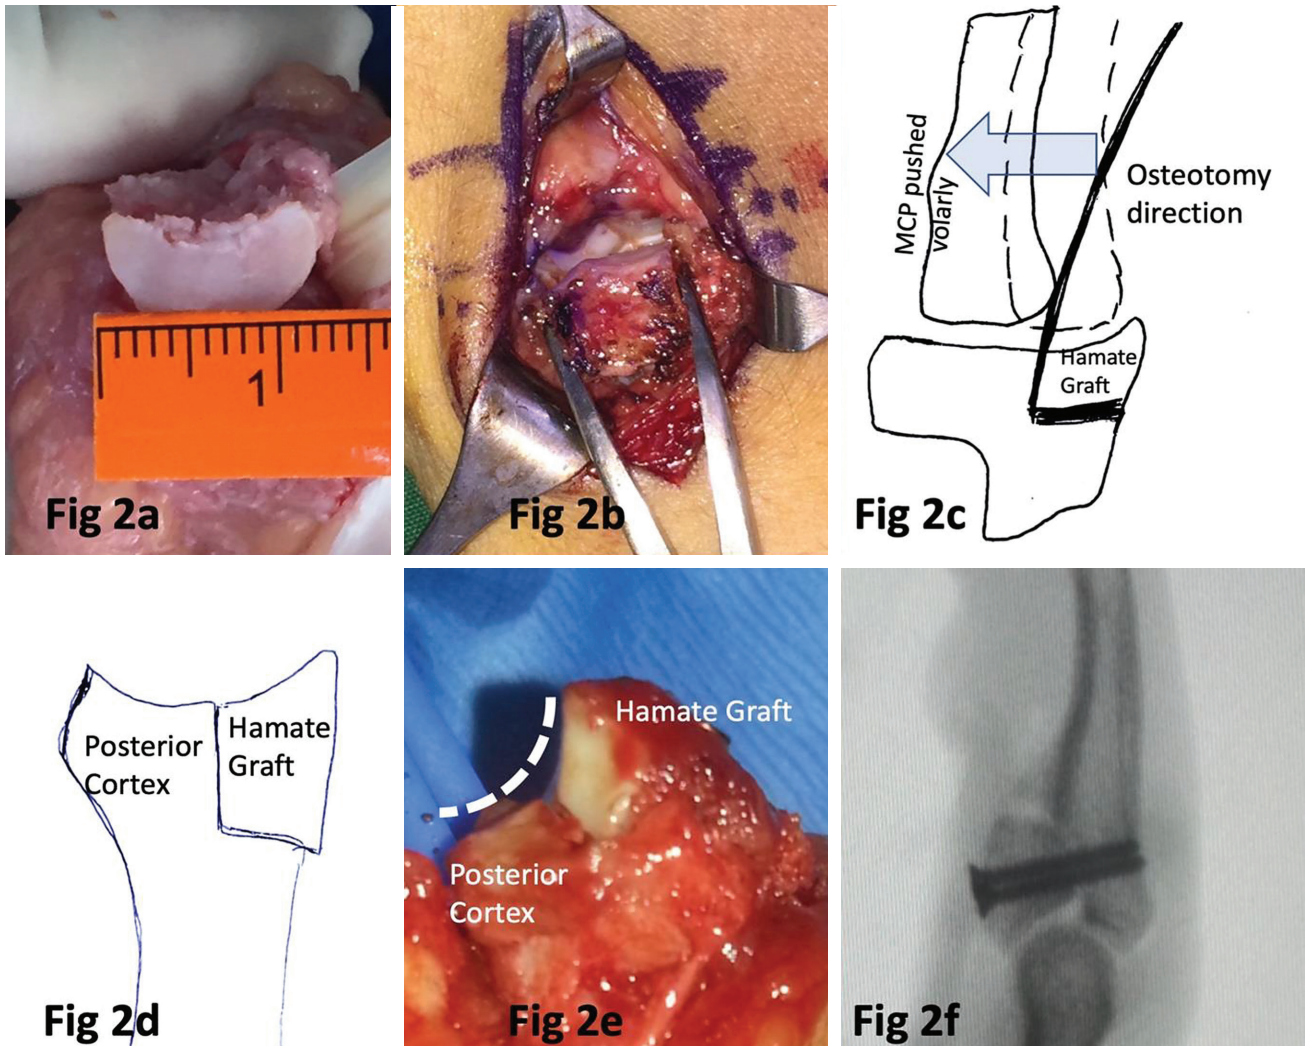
Volar lip defect prepared and measured (A). The measurements were drawn on the hamate, adding 1 mm on all dimensions (B). Osteotomy was done. Intra-articular osteotomy was done by pushing the 4th and 5th metacarpal bases volarly, with a slightly angulated position to achieve a convex surface (C). After harvest, the volar lip was reconstructed, creating a concavity of the middle phalangeal base with no cartilage step-off (D and E). Radiographs may show step-off since the cartilage of the hamate is thicker than that of the base of the middle phalanx (F).
